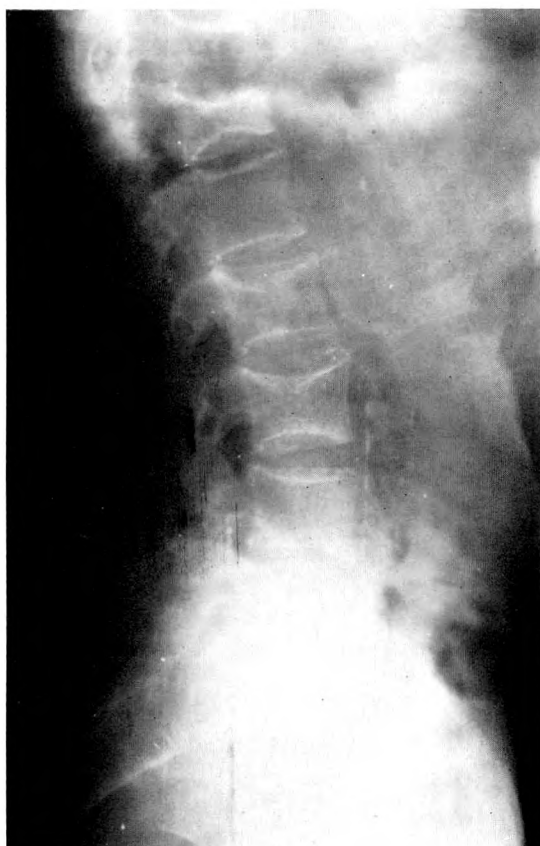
Case I. Lateral roentgenogram of lumbar spine shows collapse of T12, L2 and L3. Note the concavity of the superior end plates of the involved lumbar vertebrae and the absence of syndesmophytes.
